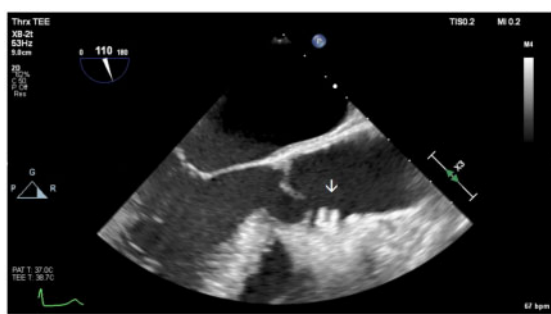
Perioperative transoesophageal echocardiography mid-oesophageal aortic valve long-axis view showing a stent protruding from the right coronary artery almost 1 cm into the Sinus of Valsalva (arrow).
